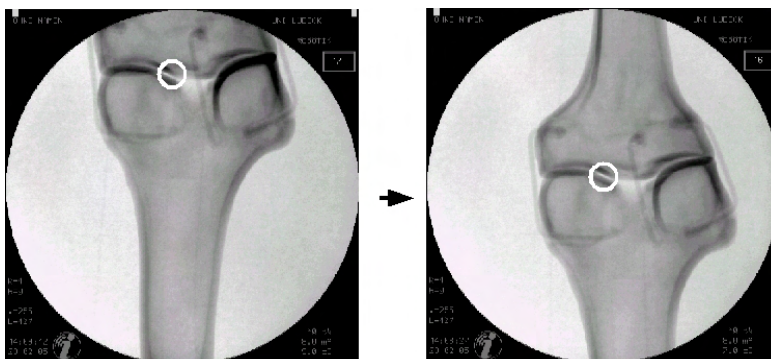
Selecting the new center on a misplaced radiograph for automatic repositioning.
